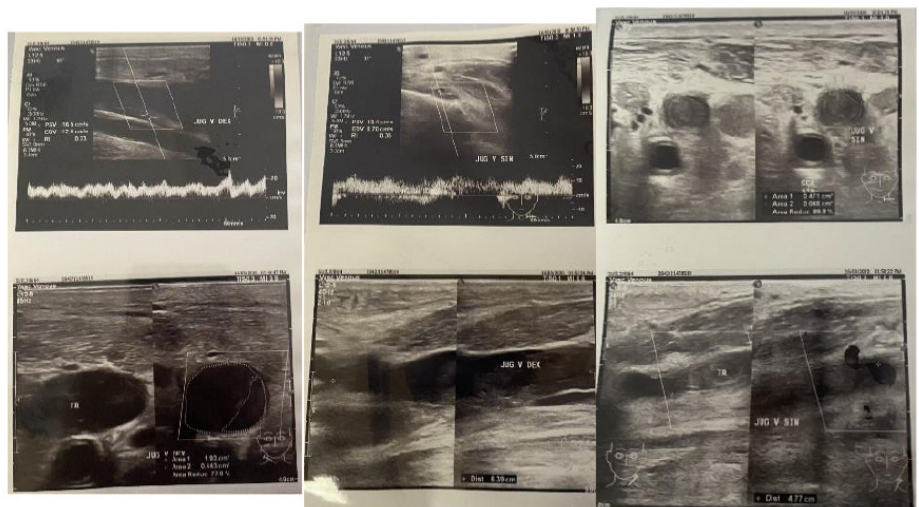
Doppler ultrasound on cervical vein
